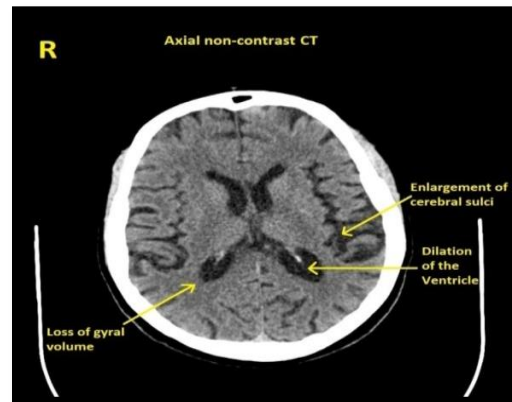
CT scan image for diagnosis of Alzheimer's disease
